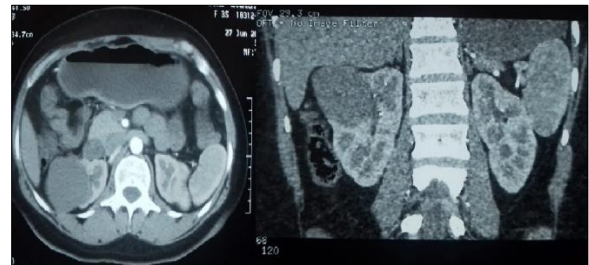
A contrast enhanced CT KUB showing a mass of 6.3×4.4×5.1 cm exophytic hypodense enhancing mass at superolateral aspect of Right kidney
